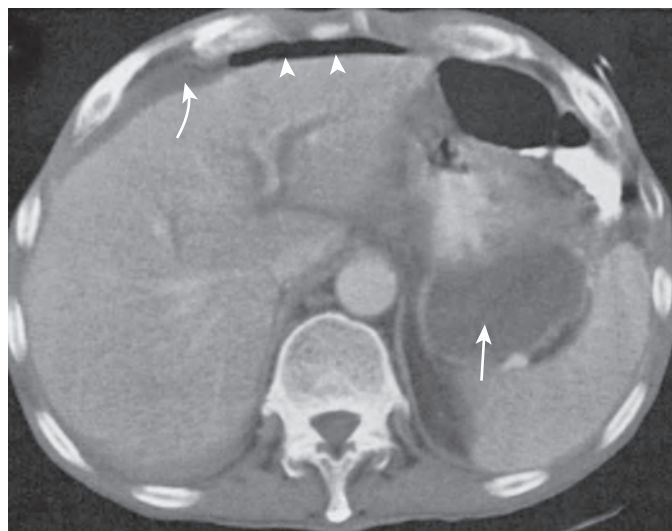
Percutaneous gastrostomy: complication. CT scan obtained 3 days after percutaneous gastrostomy. Although pneumoperitoneum (arrowheads) is often seen in the absence of clinically apparent complications, findings of loculated (straight arrow) and free (curved arrow) intraperitoneal fluid are atypical and are cause for concern. Peritoneal spillage in this case resulted from intraperitoneal positioning of a side hole of the gastrostomy tube. The patient required surgical treatment.
